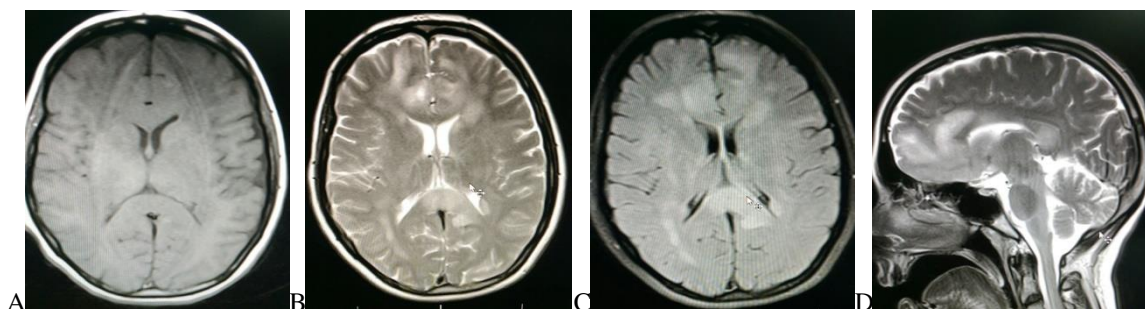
Axial T1 sequences on MRI show iso-intense to hypo-intense (frontal) multiple lesions in the periventricular, centrum semi-oval and corpus callosum (A). Axial T2 and FLAIR sequences on MRI show the same lesions that are hyper-intense (B,C). In the sagittal T2 sequences, involvement of the whole brain stem (nearly all of the midbrain, medulla, and the posterior part of pons) can be seen (D).
